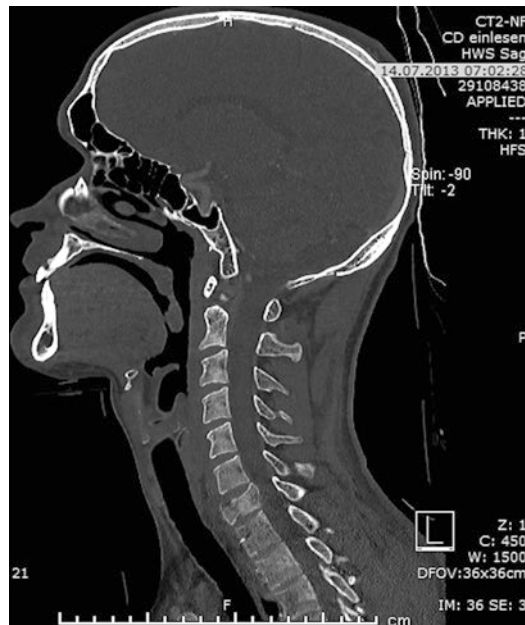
Sagittal CT scan of a C7 burst fracture in a 30-year-old male climber before surgery
